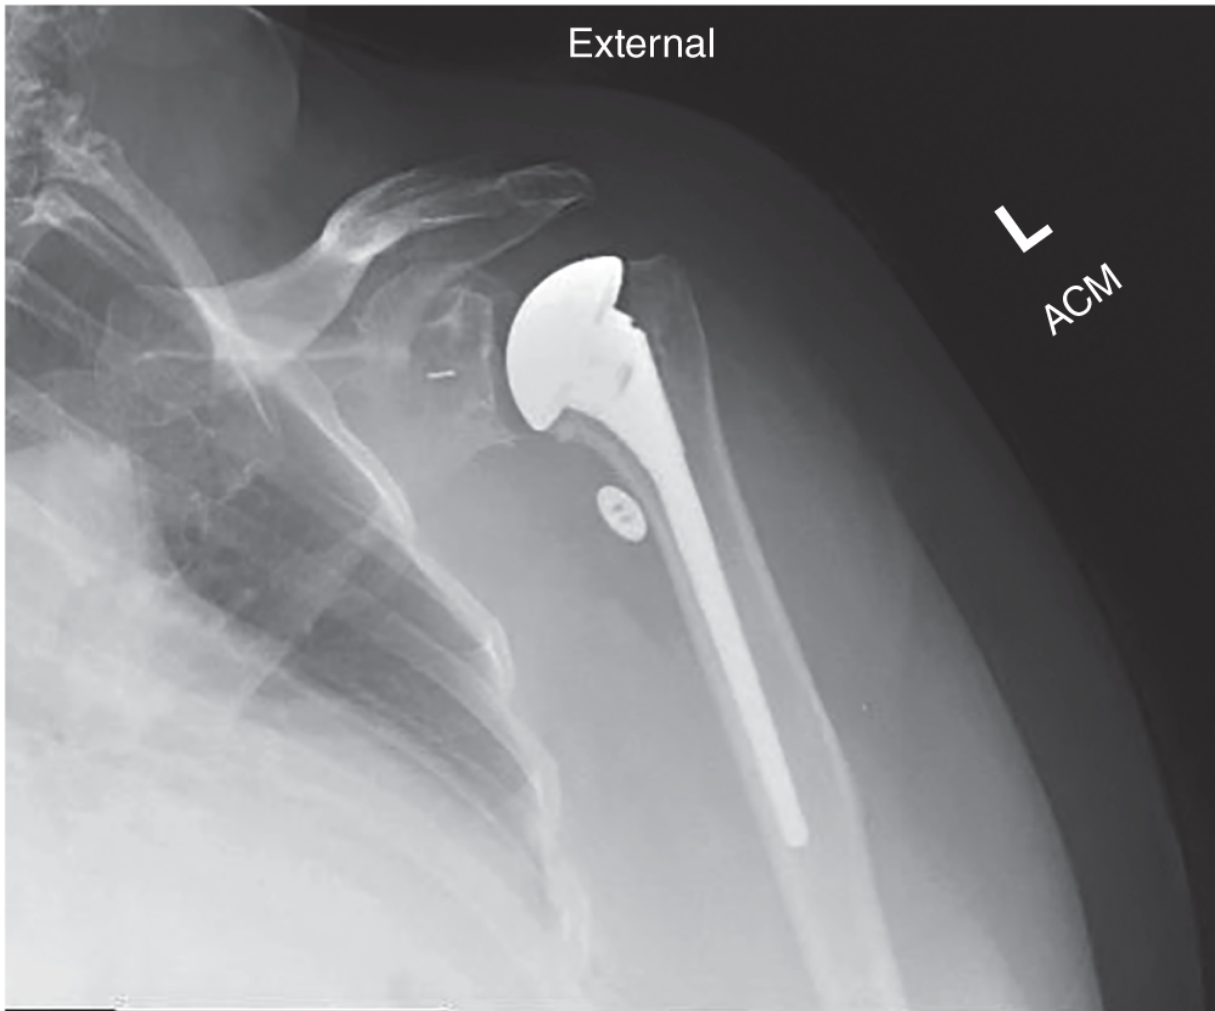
Postoperative true AP radiograph of the left shoulder showing anatomic TSA with a cemented, pegged, all-polyethylene glenoid and a press-fit humeral stem. Source: Chad Myeroff, Michael Knudsen, Michael D. McKee.
